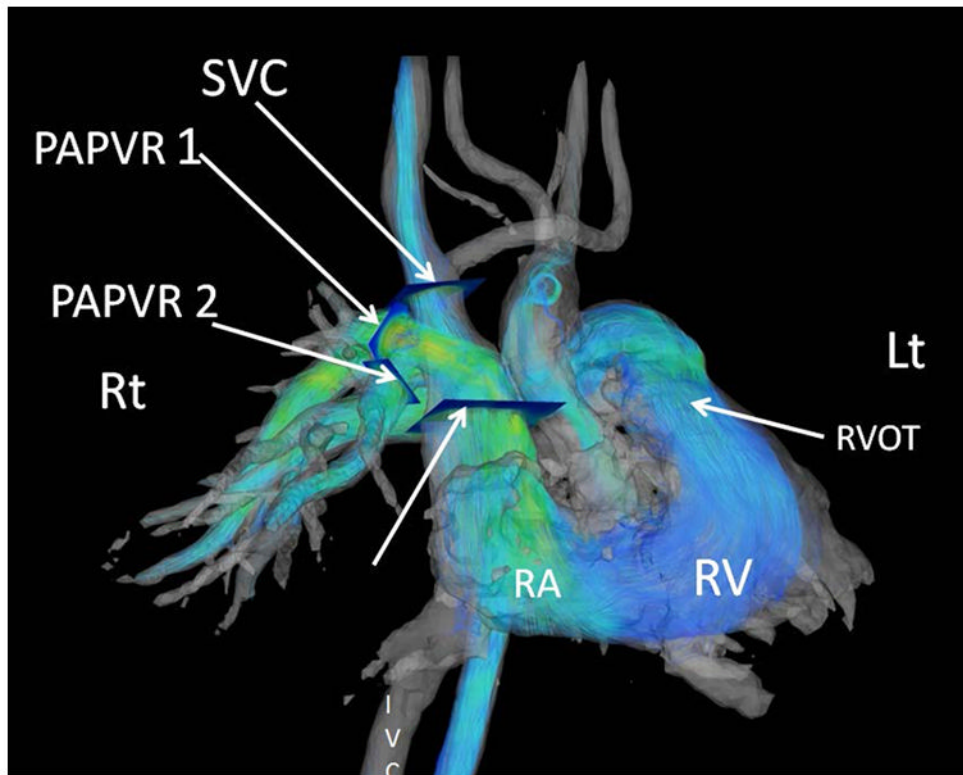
4D flow MRI of Pulmonary arterial hypertension from partial anomalous pulmonary venous return (Dana point 1.4.4)
